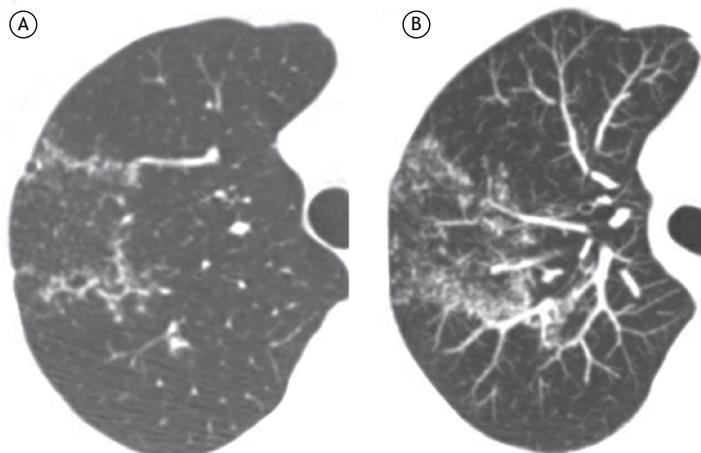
In A, axial CT image of the right upper lobe showing a reversed halo sign with nodular walls and nodules inside the halo. In B, reformatted axial image (maximum intensity projection) showing the nodules in greater detail.
